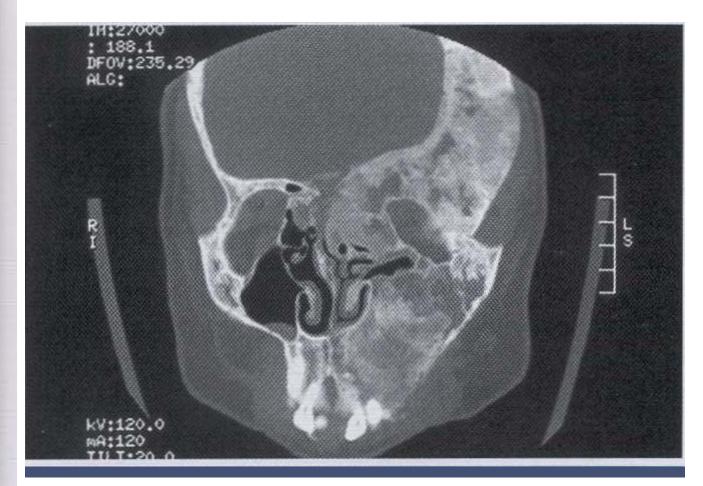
• Fibrous dysplasia. Computed tomography (CT) image showing extensive involvement of the maxilla and skull.
